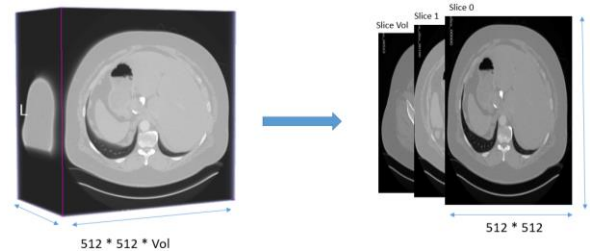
Convert 3D CT image to 2D slices
